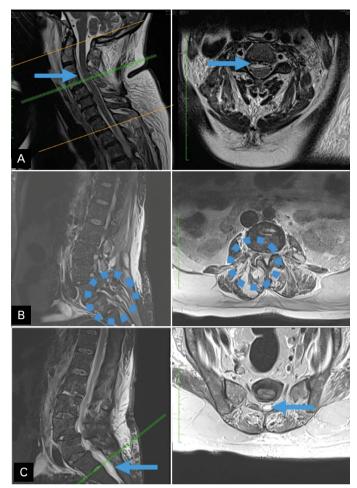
A: A cervical MRI shows a collection at the anterior level. B: facet arthritis L4L5. C: Intracanal collection at the lumbosacral level.
